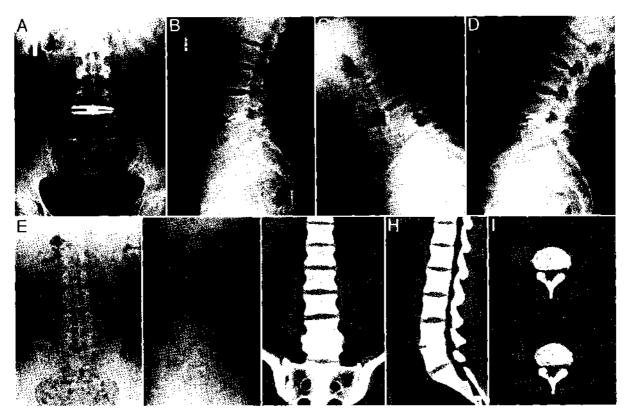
Radiographs obtained pre- and postrevision of 1 of the XL TDR devices to an XLIF fusion. A–D: Radiographs obtained 20 months after TDR. E–I: Radiographs obtained 6 months following revision to XLIF.
